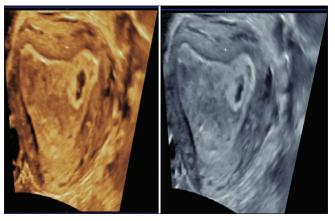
Three-dimensional ultrasonography showing implantation of intrauterine gestational sac into the left lateral superior angle of the cavity
